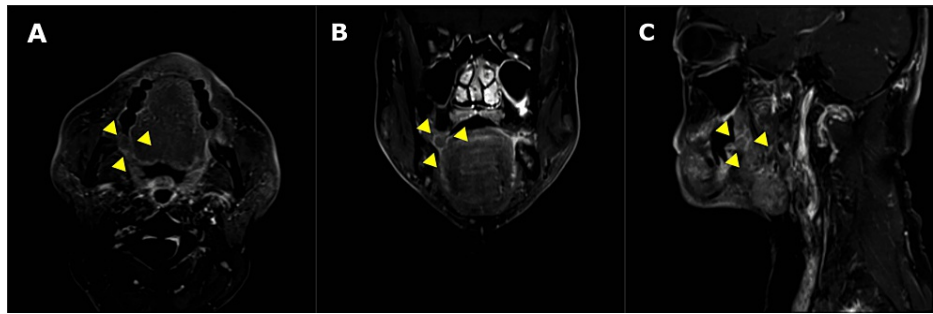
Short TI inversion recovery magnetic resonance image with contrast showing the lesion in the right retromolar area. (A) Axial plane, (B) coronal plane, and (C) sagittal plane.
